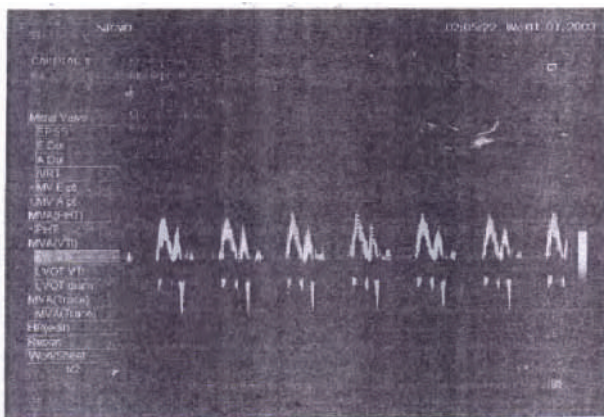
4 Standard Doppler mitral Itiflqw pattern in a healthy pregnant woman, where peak MV E/A ratio is 1.32 and deceleration time is 160 ms
